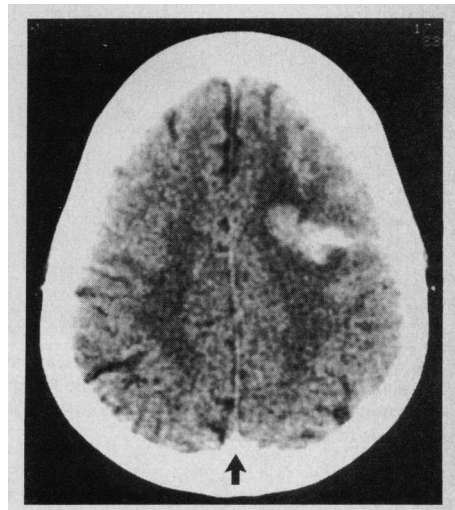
Computed tomography. Contrast-enhanced computed tomographic scan performed on day 2 shows left parietal hemorrhage and surrounding edema, but there is no lucency or "open delta" sign in superior sagittal sinus (arrow) to suggest thrombosis.
